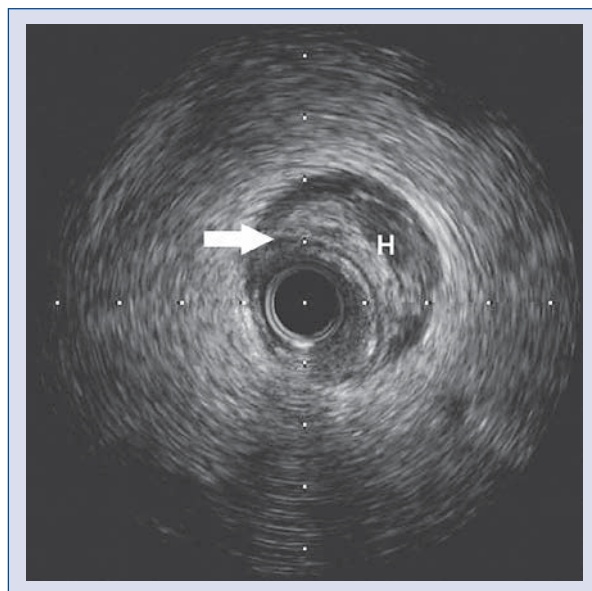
Intravascular ultrasound image showing an extensive intramural hematoma compressing the lumen of the left anterior descending artery. Hematoma (H) is clearly identifiable, external to the echo-lucent media (arrow). There is evidence of mild atheroma.
